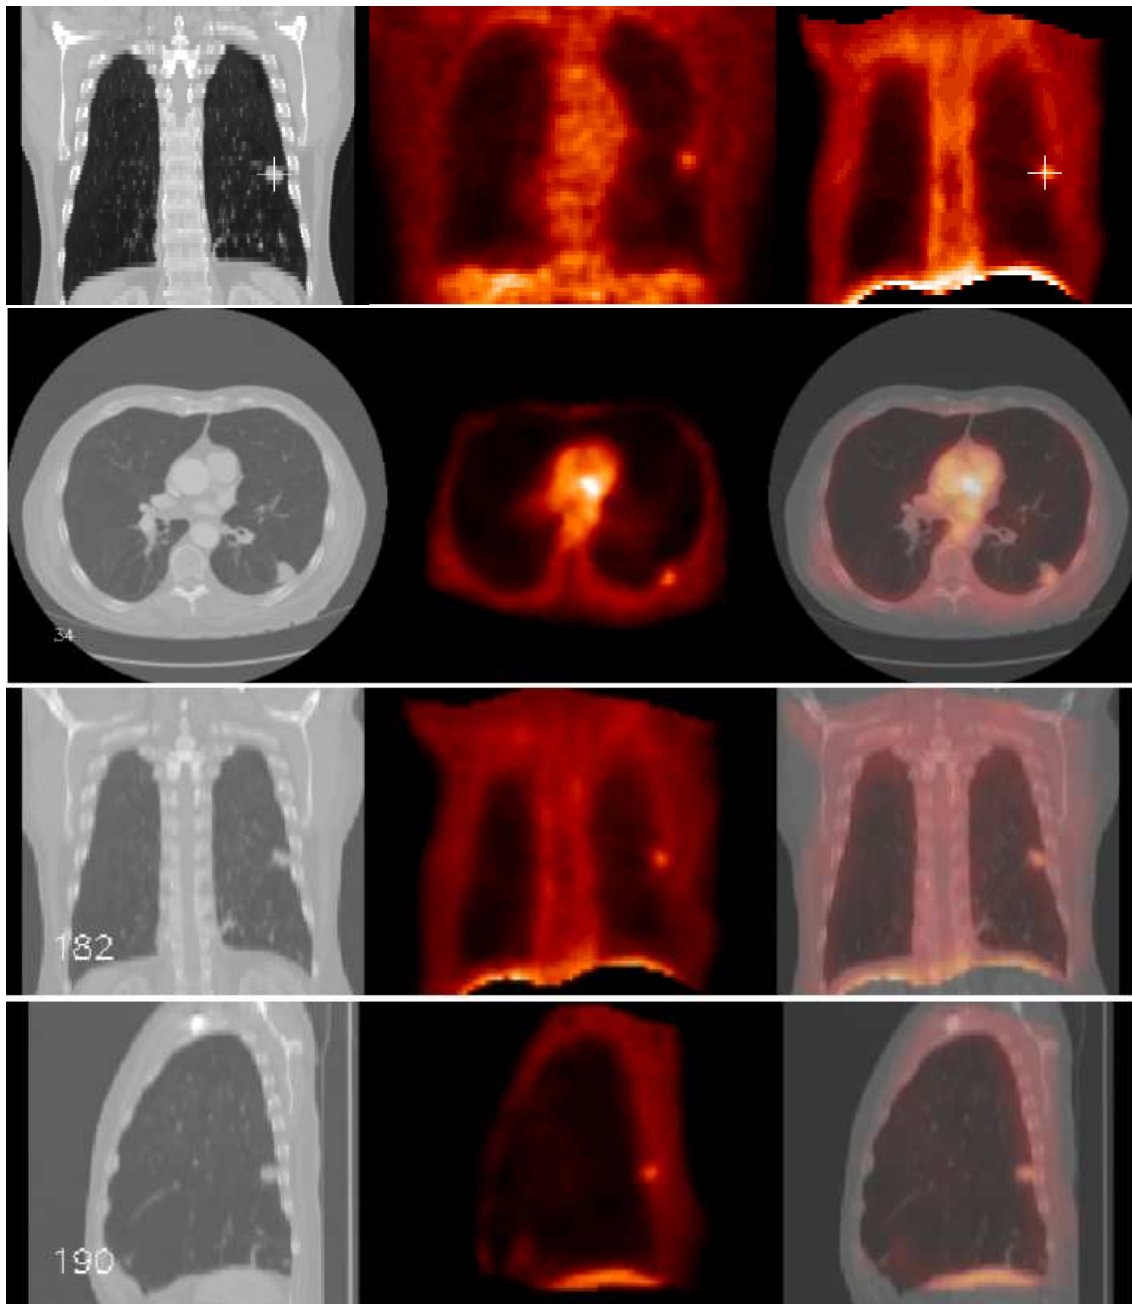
Final registration result. Case 2. 2D coronal slices (top row) of the CT image (left), the emission PET image registered with a linear transformation (center) and the emission PET image registered with the proposed non-linear registration methodology (right). The mark on the top row points out where the tumor is located. It can be seen that the tumor is found in different coronal slices after applying a linear transformation (center) and that this problem is solved using the proposed non-linear registration methodology (right).
